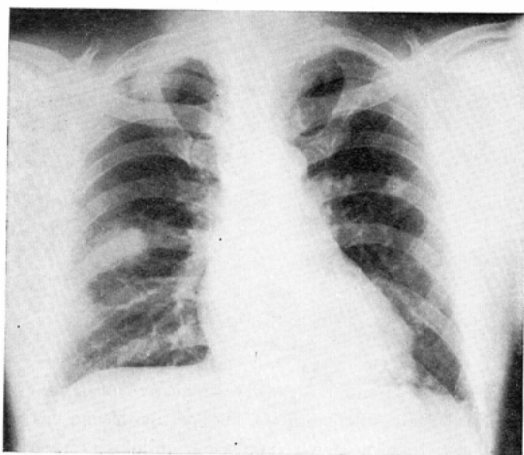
Chest X-ray film in October 1972 showing nodular densities in the apex of the right lung and middle lung field. Mottling shadow and scar in the apex of the left lung are seen.
